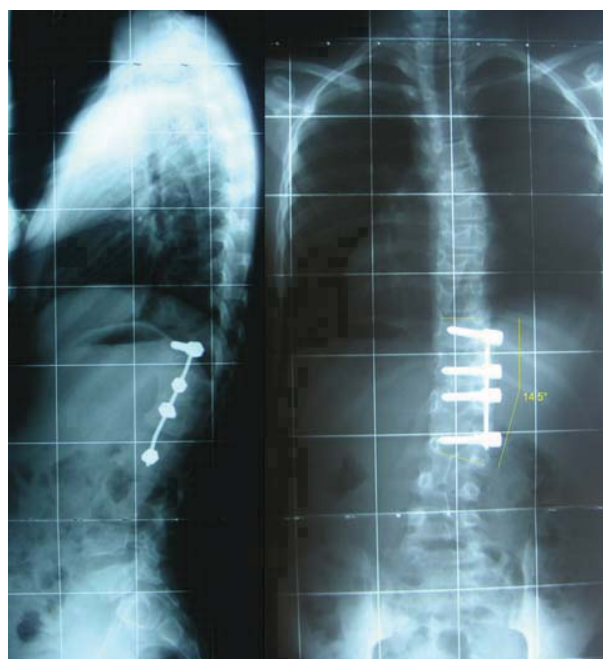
Follow-up radiographs of the spine 8.5 years later showing a balanced spine with satisfactory fusion in the coronal plane and residual thoracolumbar kyphosis
